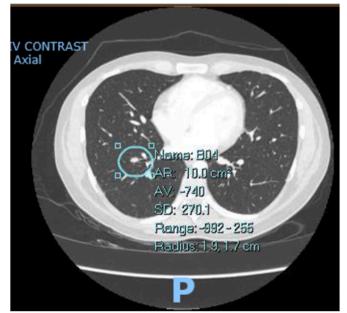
CTA chest showing right lower lobe pulmonary embolus.
